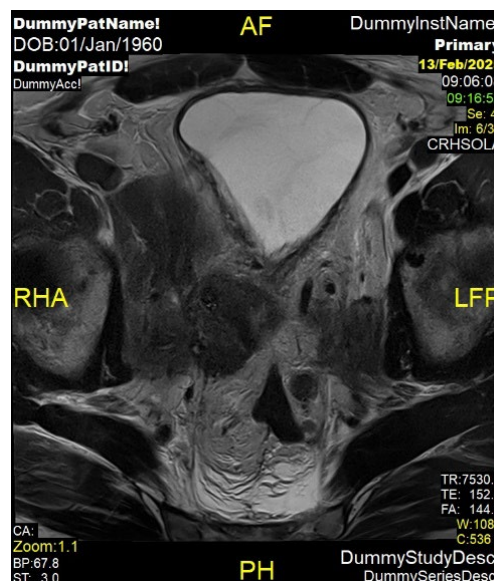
Axial T2 MRI through the pelvis showing bilateral low signal pelvic masses.
